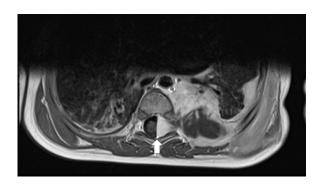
Chest magnetic resonance imaging (MRI). Chest magnetic resonance imaging (MRI). Axial contrast-enhanced T1-weighted, lesion adjacent to the intervertebral foramen of spinal nerve T7, with invasion of the spinal canal. The lesion occupied 50% of the epidural space and displaced the spinal cord to the right (arrow), without evidence of spinal injury. Several lobulated masses were observed on the lateral and anterior pleural spaces
